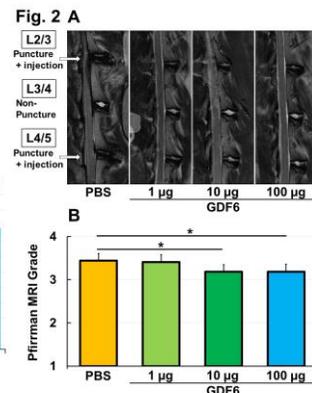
(A) Representative cases (MRI T2 sagittal view)
